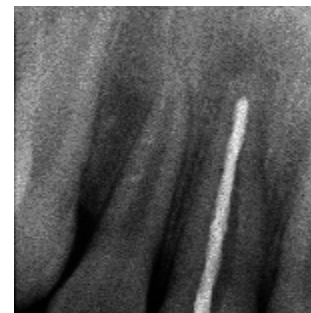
Estimation of working length by digital radiograph .
